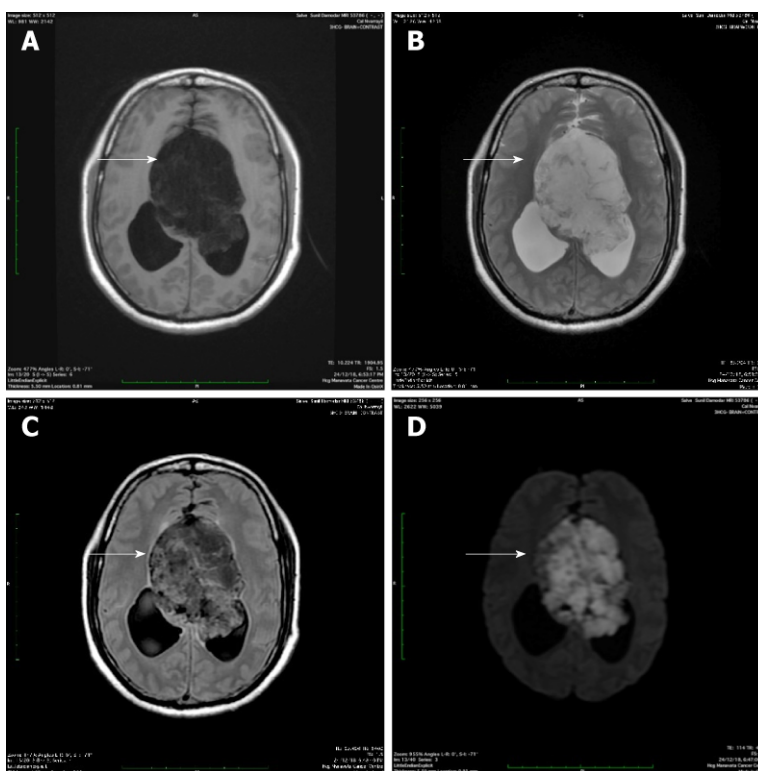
Magnetic resonance imaging. Magnetic resonance imaging revealed a large, lobulated and septated lesion arising from the third ventricle that was: A: Hypointense on T1 weighted imaging; B: Hyperintense on T2 weighted imaging; C: Heterogeneously hyperintense on T2 axial FLAIR imaging; D: Appeared diffusely restricted on diffusion weighted imaging.
